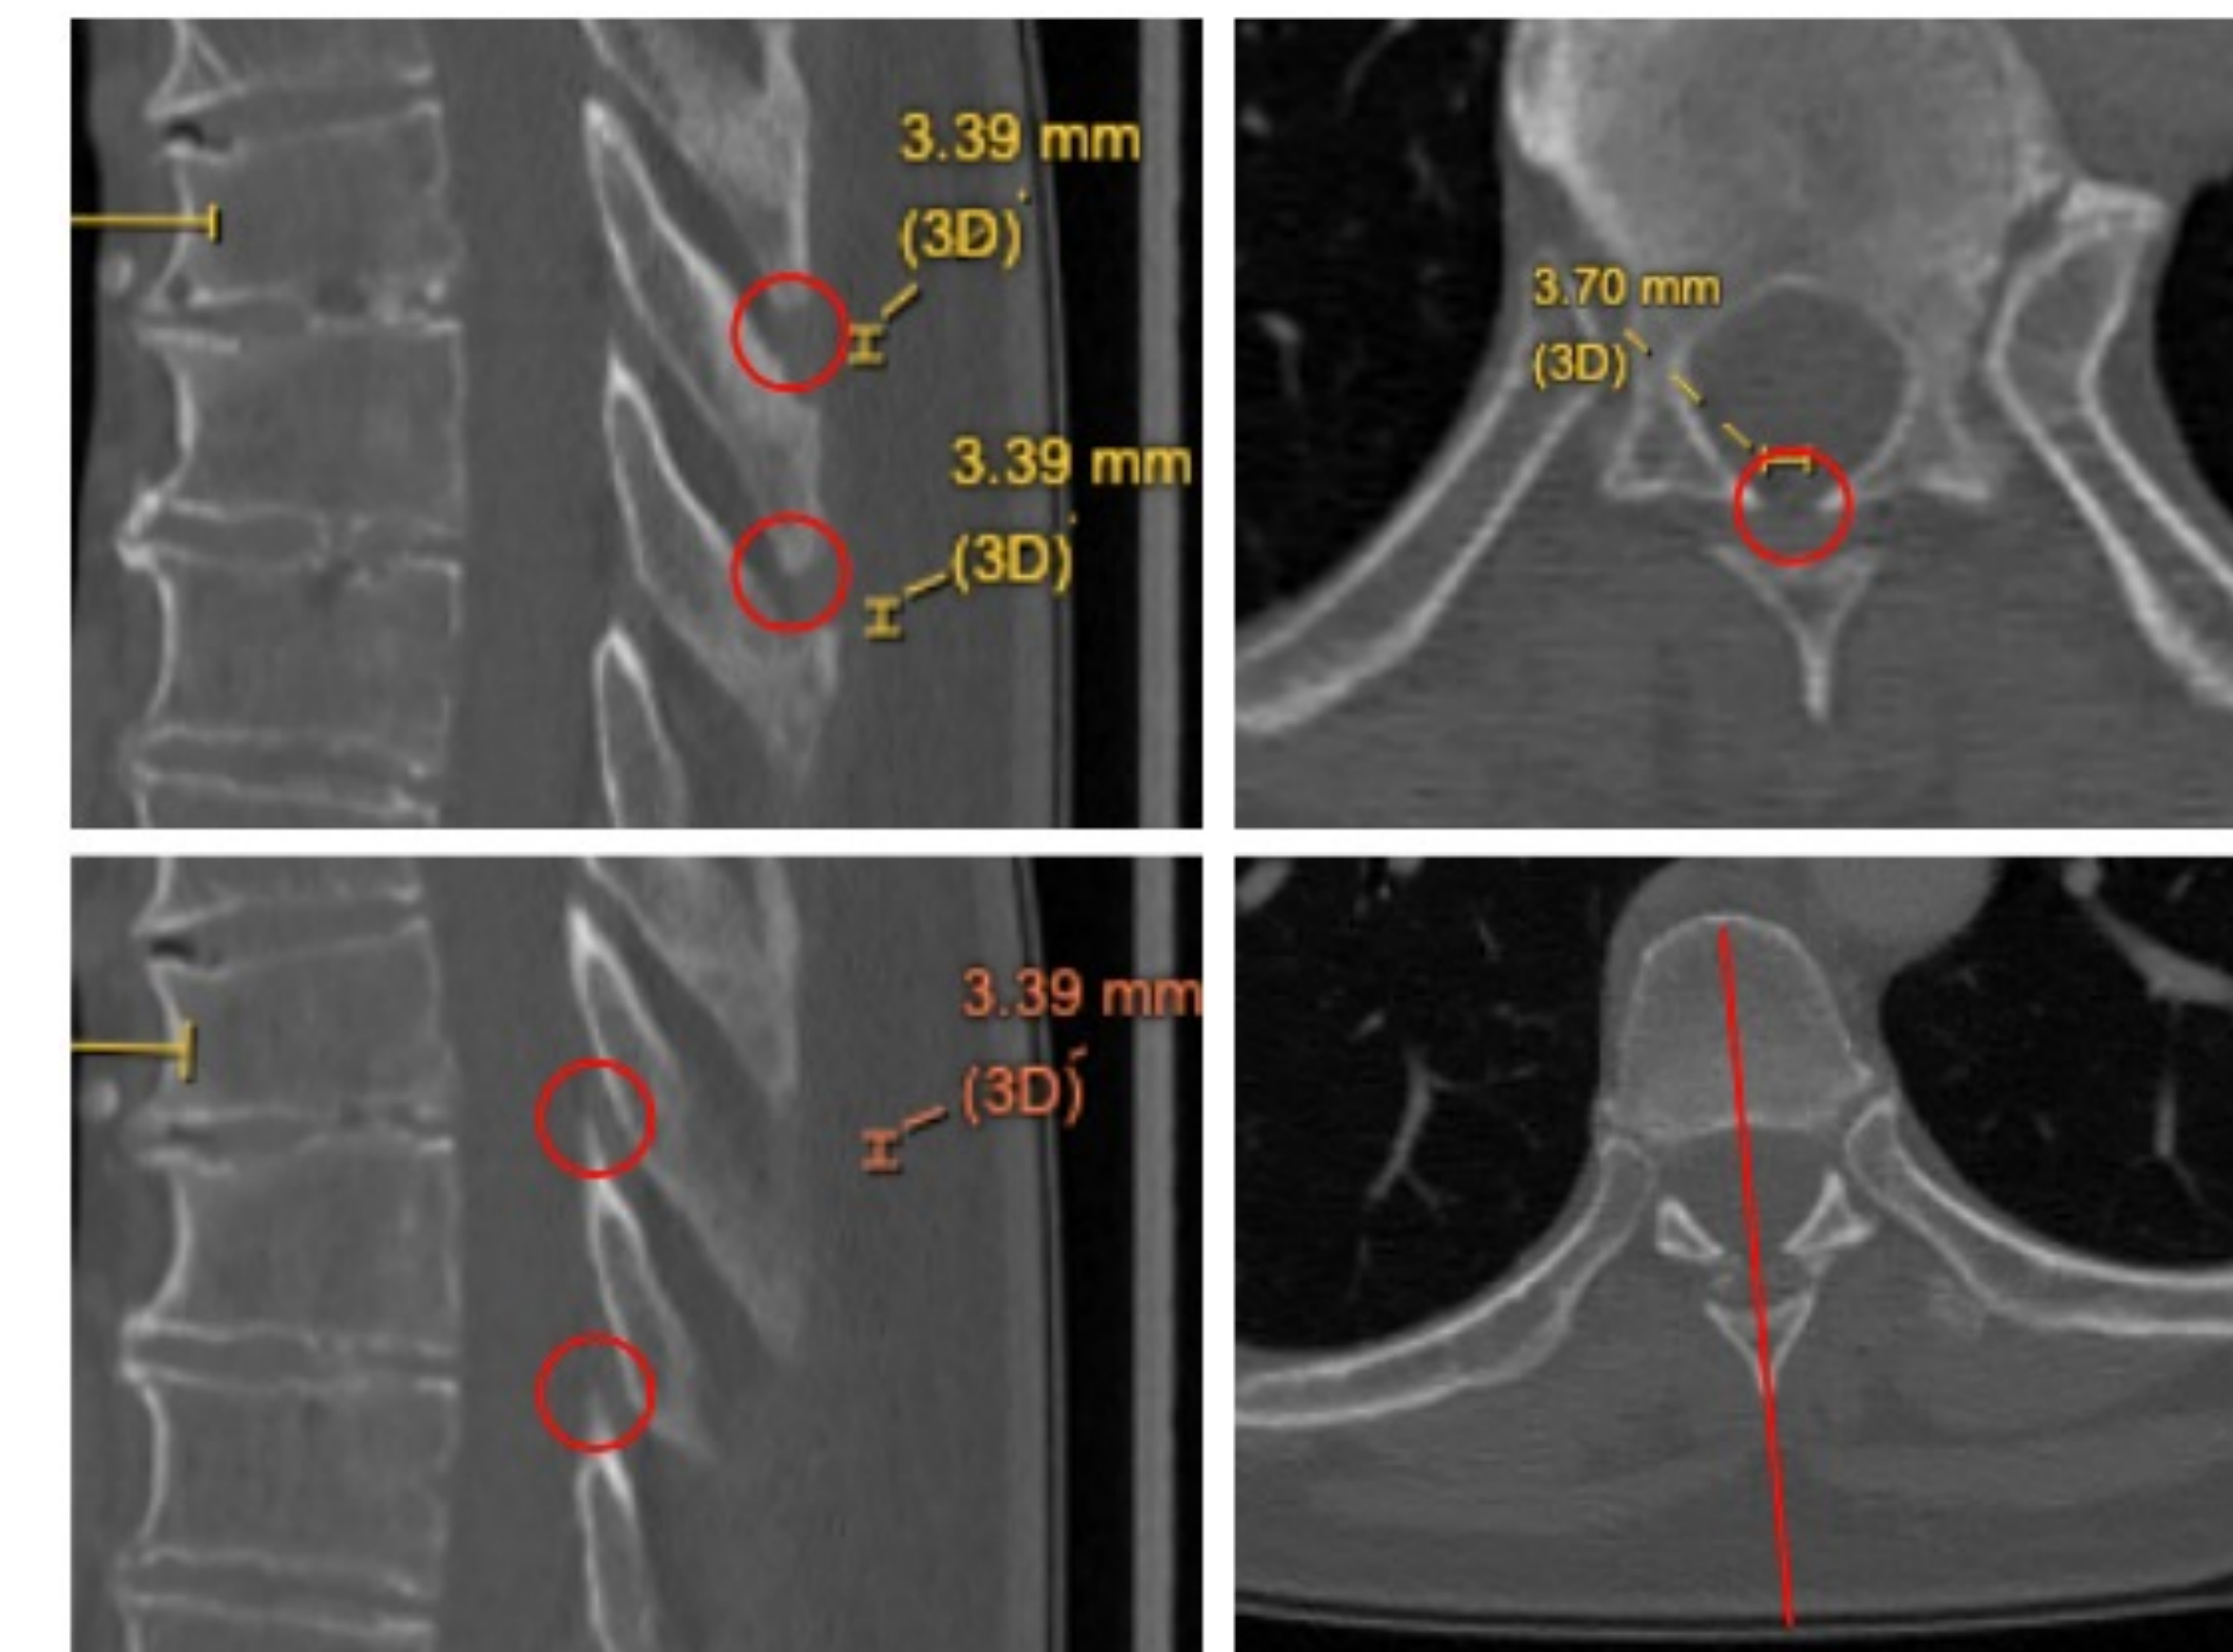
CT scan representing closed spaces
